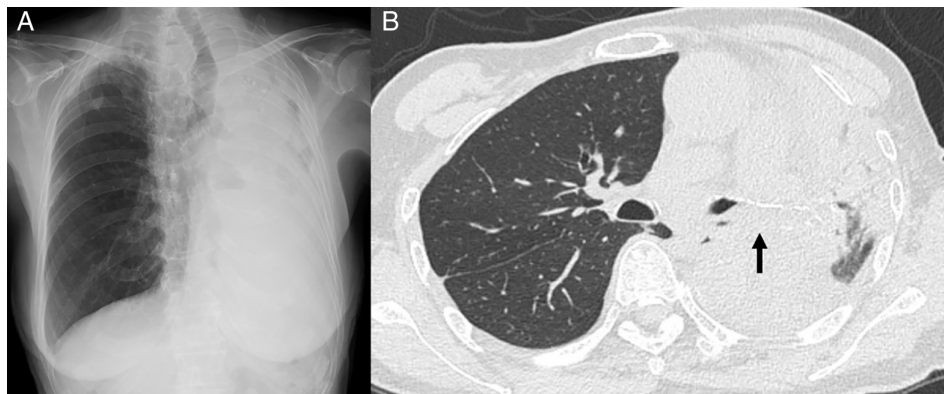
(A) Chest X-ray showing left pulmonary atelectasis. (B) Chest computed tomography revealing a completely occluded left main bronchus.
